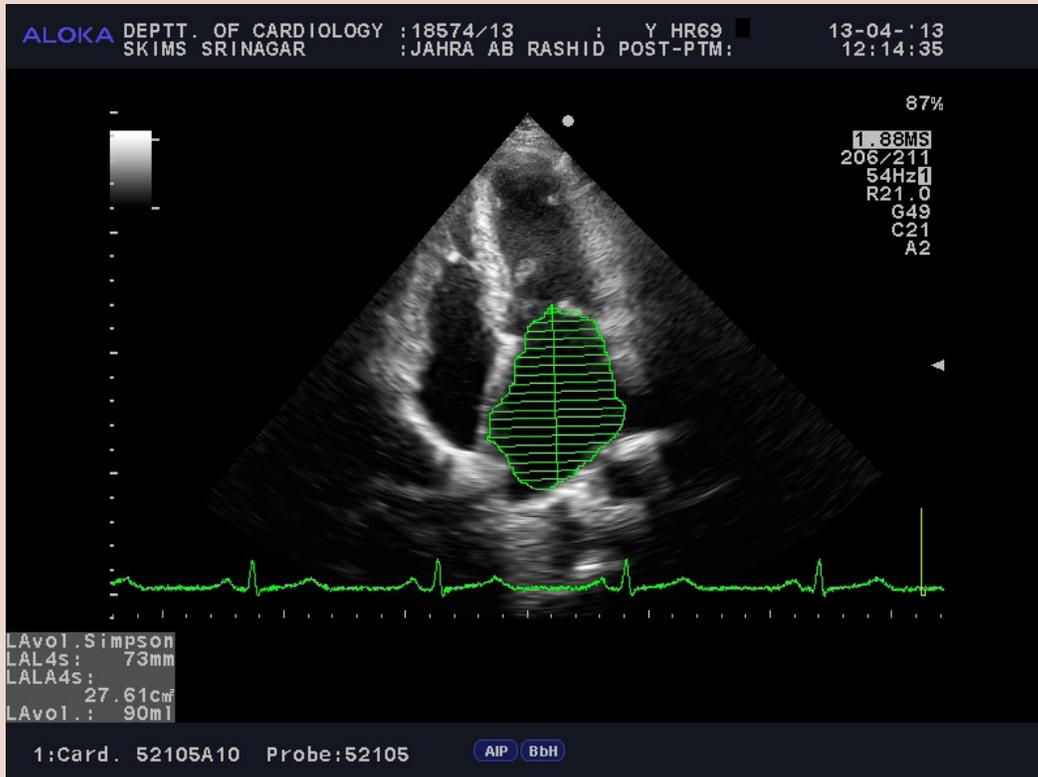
Measurement of maximal LA volume (V_{max}) by modified Simpson's method in apical 4-chamber view.
